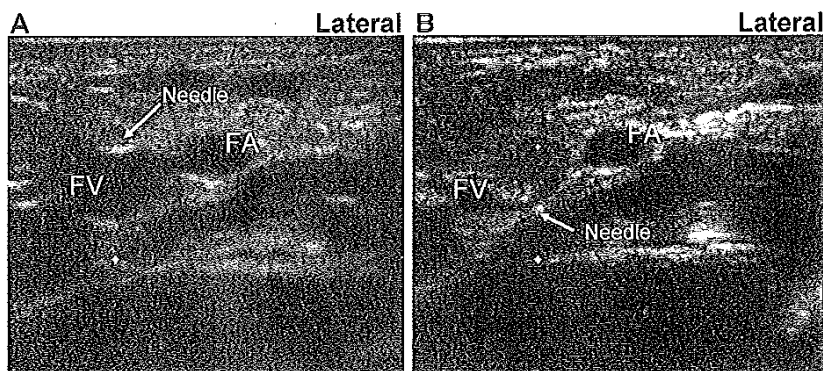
(A and B) Ultrasound images of the left femoral vessels in newborn child. In (A), the artery (FA) and vein (FV) are clearly seen with the needle on the anterior wall of the vein. In (B), the needle has been advanced further causing the vein to be compressed. When cannulating small veins, it is common for the vein to be compressed in this way. Overly tentative advancement of the needle will often lead to failure in cannulation. Assuming no vulnerable structure lies deep to the vessel, it is often advisable to aim to transfix the vessel (with a careful, visualized, short thrusting movement) then withdraw the needle without imaging (while aspirating) until free flow of blood is seen.
